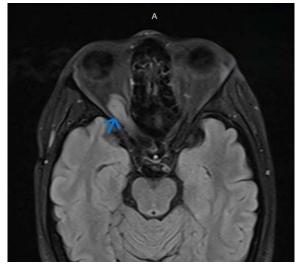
Magnetic resonance imaging fragments of Patient U., 25 years old.
